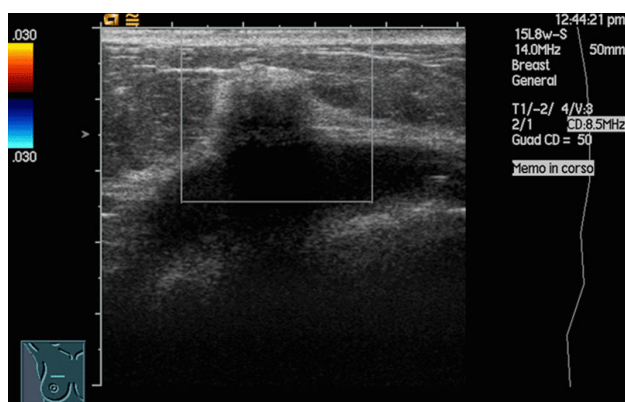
Right breast ultrasound imaging
